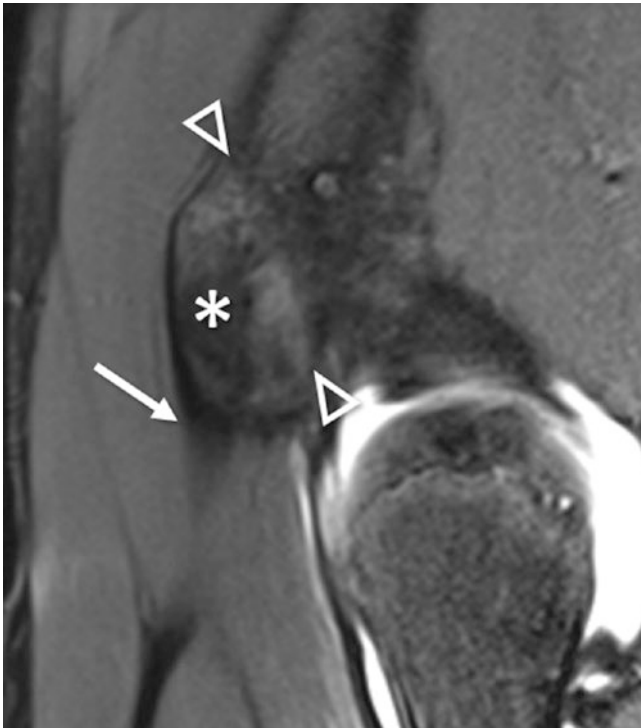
Subspine impingement in a 14-year-old female soccer player with previous apophyseal avulsion. Sagittal PD fat-suppressed MRI shows widened and irregular apophyseal gap (arrowheads) and displacement and enlargement of the anterior inferior iliac spine (asterisk). Note origin of the rectus femoris tendon (arrow)
